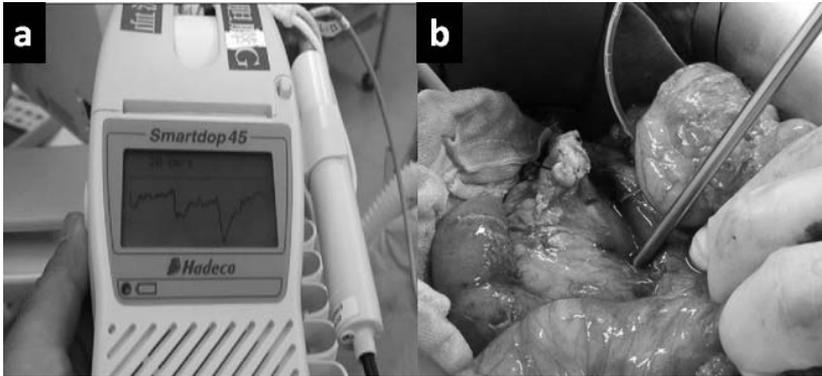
Intraoperative vessel detection and tracking of an artery around the pancreas head using Doppler blood flowmeter. (a) Displayed waveform of vessel blood flow in the device LCD, (b) Real time tracking of the artery using a thin, rod-shaped ultrasonography probe.
